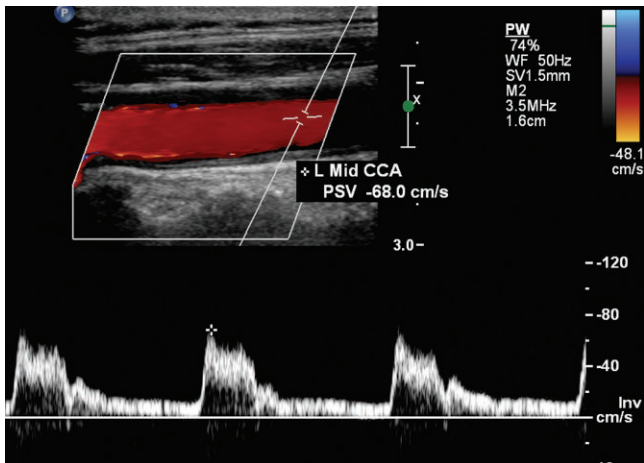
Left common carotid artery spectral and color Doppler shows the velocity is 68 cm/s.
